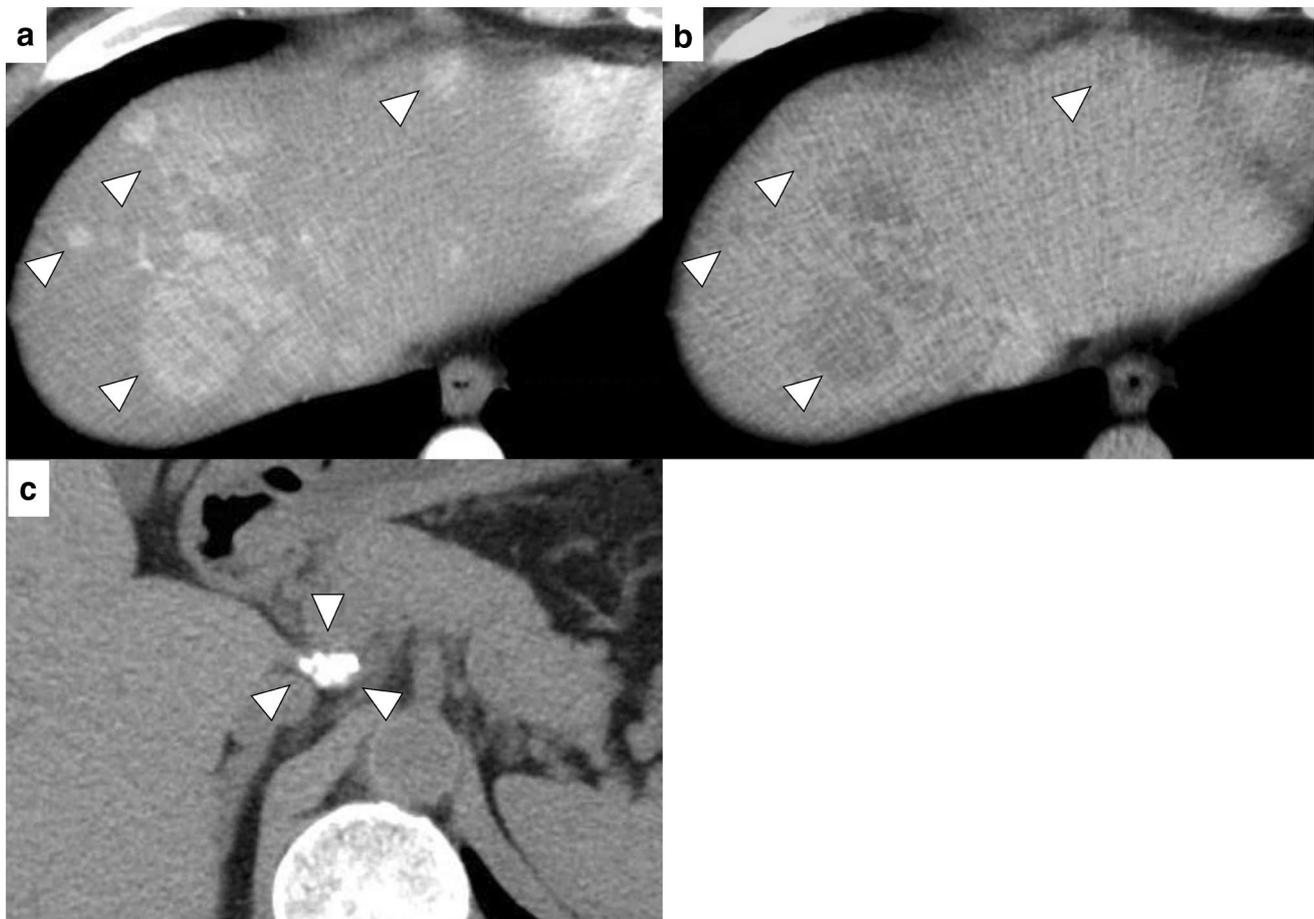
a Contrast-enhanced computed tomography (CT) showed multiple masses with early phase enhancement (arrow heads) and b late-phase washout (arrow heads) in both lobes. c CT revealed enlarged intraabdominal lymph nodes with calcification (arrow heads)
